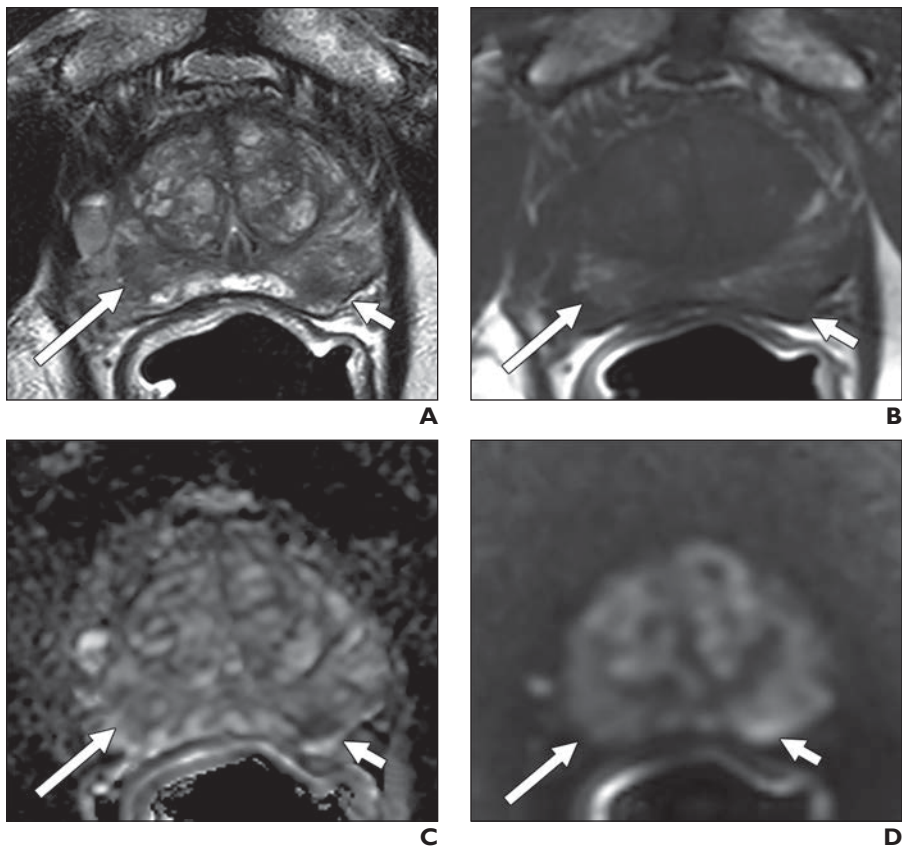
77-year-old man with serum prostate-specific antigen value of 6.12 ng/mL who was referred for multiparametric MRI (mpMRI); 3-T mpMRI examination was performed with endorectal coil. A, T2-weighted image shows right-sided (*long arrow*) and left-sided (*short arrow*) lesions along with patchy peripheral zone. B, Axial T1-weighted image shows biopsy-related residual hemorrhage within right-sided lesion (*long arrow*) and “hemorrhage exclusion” sign within left-sided lesion (*short arrow*). C and D, Apparent diffusion coefficient map (C) and high-b-value DW image (D) show hypointense and hyperintense signal features within left-sided lesion (*short arrows*) that are suspicious for prostate cancer, but signal-intensity features appear normal within right-sided lesion (*long arrows*); this difference in findings is example of potential source of false-positive lesion at T2-weighted prostate MRI secondary to biopsy-related residual hemorrhage.
